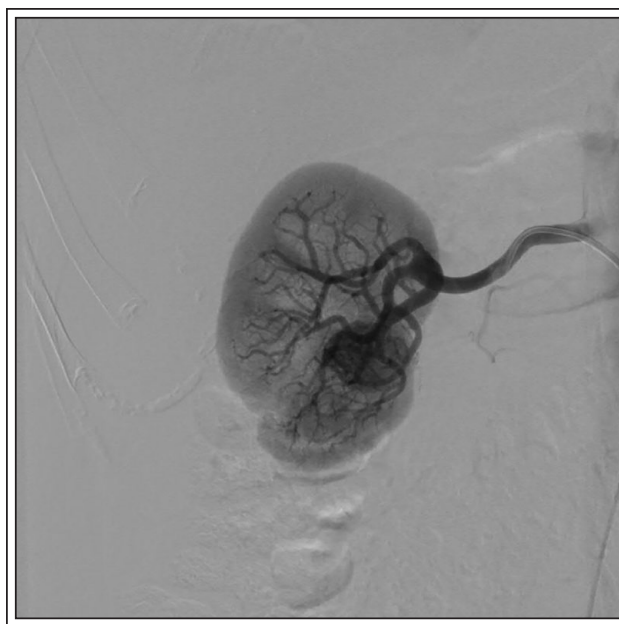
IR renal arteriography demonstrated a focal 2.5 cm hyperdense lesion at the medial aspect of the mid pole kidney near the renal hilum which corresponded to the abnormal area evidenced on previous CT scan. No pseudoaneurysm was identified.
